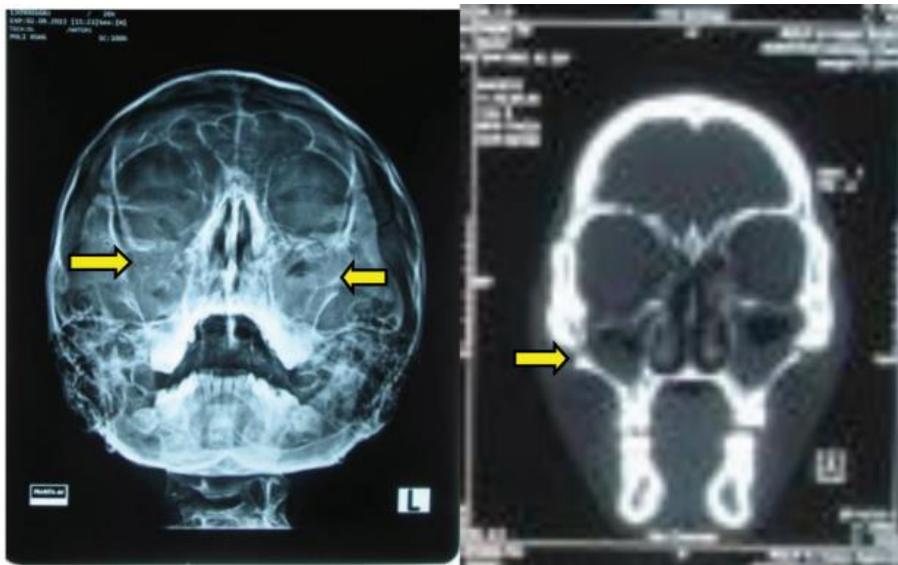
Imaging findings of a Le Fort II fracture. (A) Waters view radiograph demonstrating bilateral fracture lines of the zygomaticomaxillary buttresses (yellow arrows). (B) Coronal CT image showing fracture fragments along the orbital floor and maxillary sinus walls (yellow arrow).¹⁹
